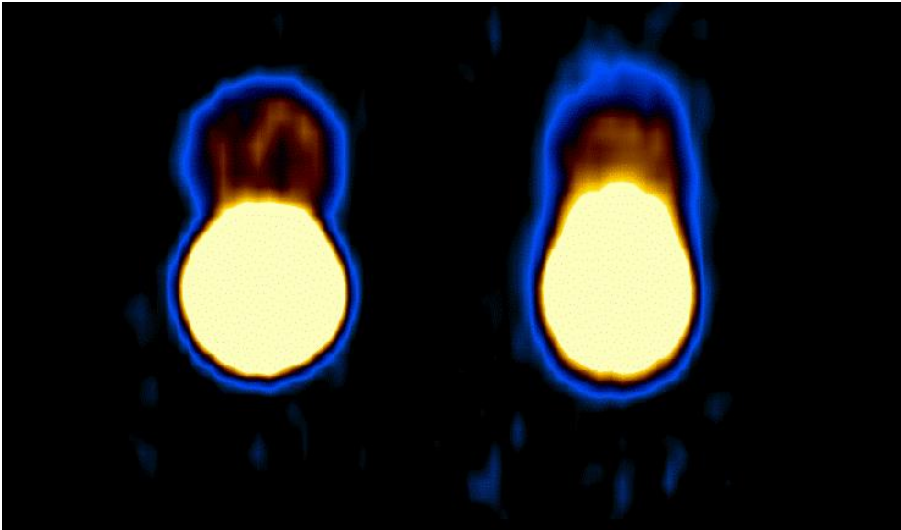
PET image of a FDG lesion with high tracer activity uptake in the bottom and low tracer activity uptake in the top. Left, a static PET scan with no motion during PET acquisition. Right, with 15mm motion amplitude throughout PET acquisition producing motion blur of the lesion.
